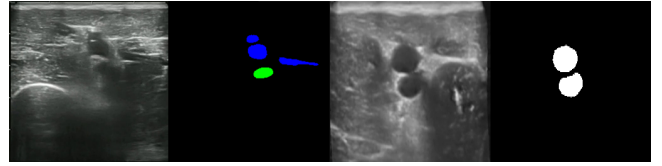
Raw ultrasound image and label (left) and sliced augmented image and label (right)
